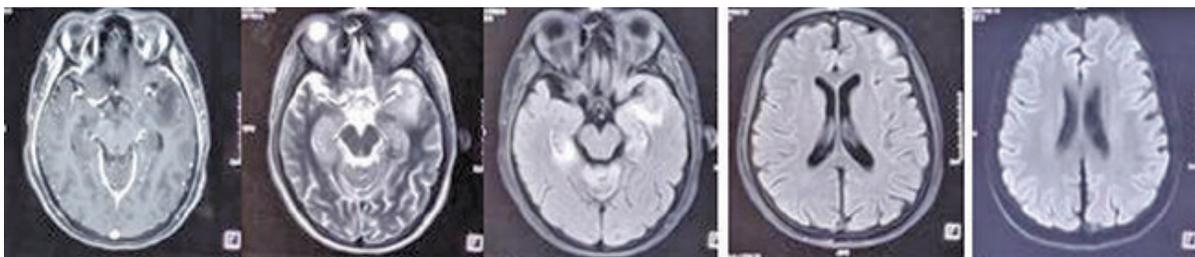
MRI of the brain showing T1 hypo intensity, T2WI, and FLAIR hyperintensity in both temporal and left frontal cortico-subcortical areas
